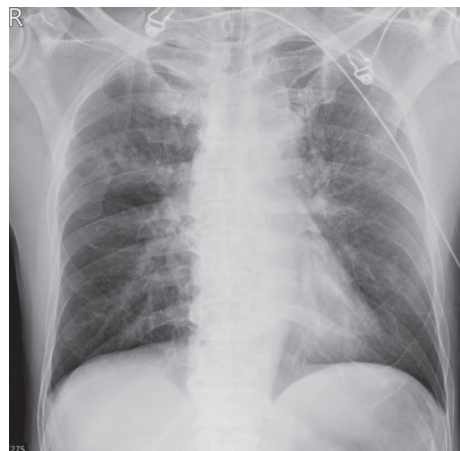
Initial chest plain film taken at the emergency room.
